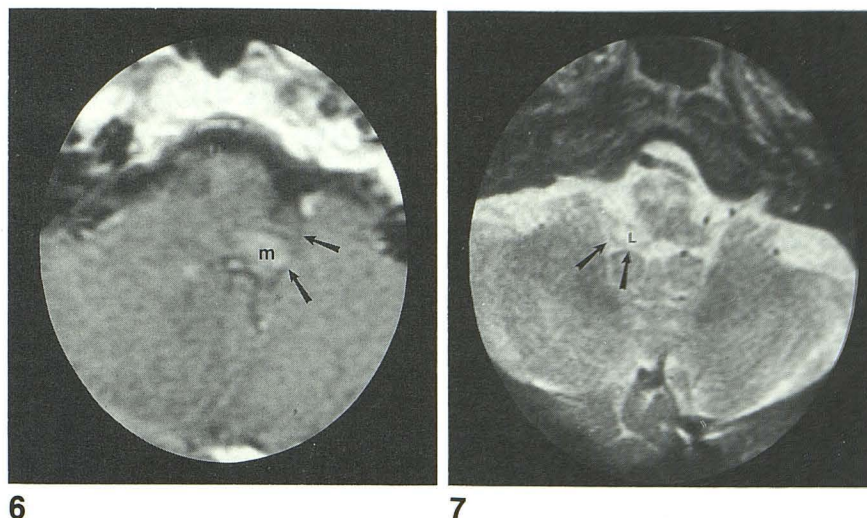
Axial contrast-enhanced MR image (1.5 T, 567/20, 3-mm section thickness), patient seven, metastatic breast cancer. Contrast-enhancing mass (*m*) expanding the left rostr dorsolateral medulla. Despite the local distortion and the slight obliquity of the section, CSF in the foramen of Luschka (*arrows*) provides a reliable landmark for the CNC. Autopsy 11 months after MR imaging showed metastatic breast cancer involving the CNC.
